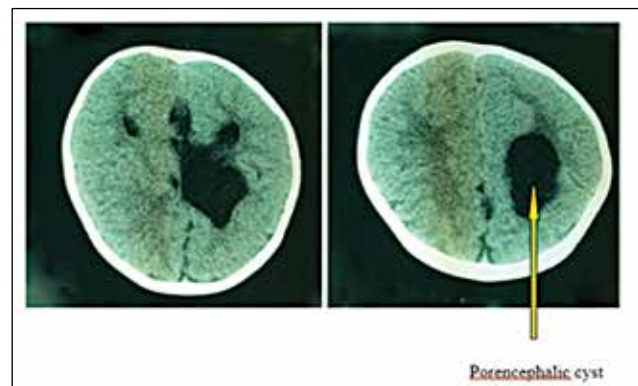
CT scan of brain showing porencephalic cyst in left fronto-parietal region
